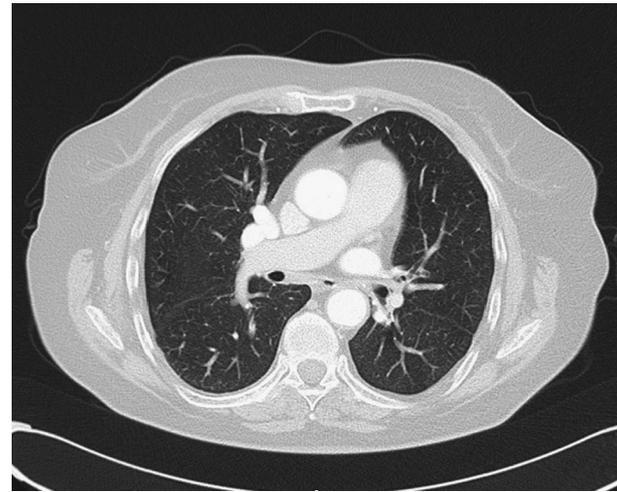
Computed tomography scan of chest.
